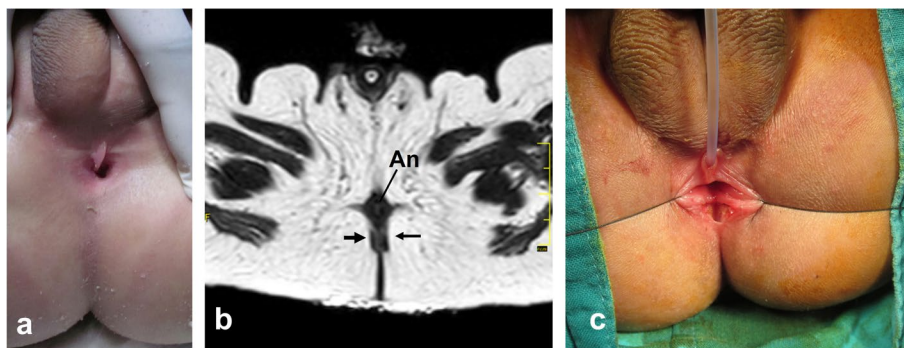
A case with abnormal communication between the lower urinary tract and the anus (3rd case). a Associated mild anterior anal misplacement. b Confirmation of anterior anal misplacement in MRI. An: anal canal, black arrows point to normal anal position. c Simple posterior anoplasty (cut-back) to manage constipation in this case
